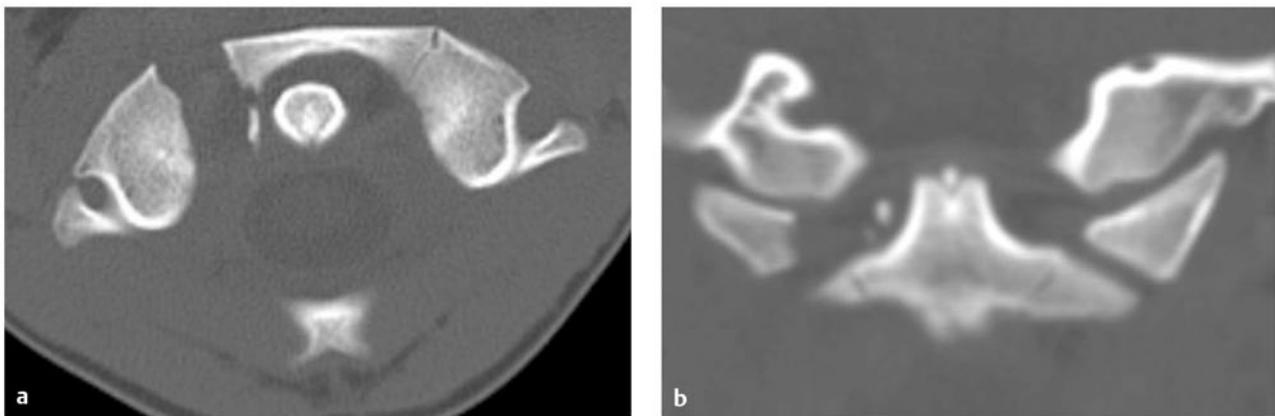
Jefferson fracture. (a) Axial and (b) coronal computed tomographic (CT) scans demonstrating fracture through the right anterior arch and lateral mass of C1. If the sum of the total lateral overhang of the C1 lateral masses on C2 is ≥ 7 mm on odontoid view radiographs or coronal CT, then disruption of the transverse ligament should be suspected (the “rule of Spence”).¹¹⁹
